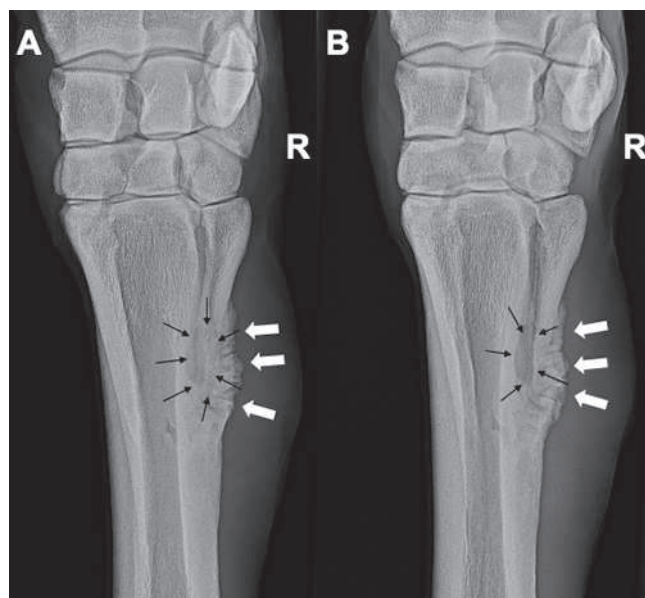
Radiographic images of the right carpus showing the proximal part of MCVI, which was left in situ after partial ostectomy in case 4 (15 weeks after surgery). (A) Dorsopalmar and (B) dorsolateral-palmaromedial oblique views. An exuberant amount of spiculated irregular periosteal bone formation is evident on the remaining MCVI (white arrows). A well-defined radiolucent area in the metacarpal interosseus space between MCIII and MCIV is indicative of bone lysis (black arrows). | Röntgenologische Aufnahmen des rechten Karpus stellen den proximalen Abschnitt des MCIV dar, welcher bei Fall 4 während der partiellen Ostektomie in situ belassen wurde (15 Wochen nach der chirurgischen Therapie): (A) Dorsopalmar Aufnahme und (B) dorsolaterale-palmaromediale Schrägaufnahme. Eine übermäßige Menge an unregelmäßigen, gezackten periostalen Knochenzubildungen des verbliebenen MCIV-Abschnittes ist sichtbar (weiße Pfeile). Ein klar umschriebener, strahlendurchlässiger Bereich innerhalb des Spatium metacarpeum interosseum zwischen dem MCIII und MCIV weist auf Knochenlyse hin (schwarze Pfeile).
